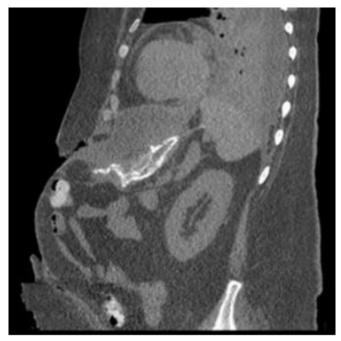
The CT scan view of a metallic stent placed for a fistula after sleeve gastrectomy.
